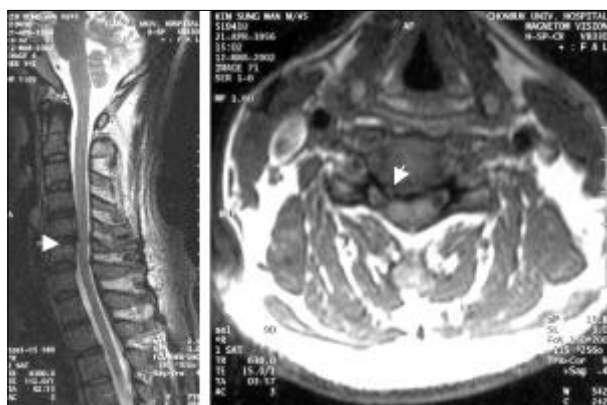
Magnetic resonance image of patient 1 shows a herniated nucleus pulposus at the C5-6 level on the right paramedian side focally (white arrow) but no evidence of disc herniation on the left side.
